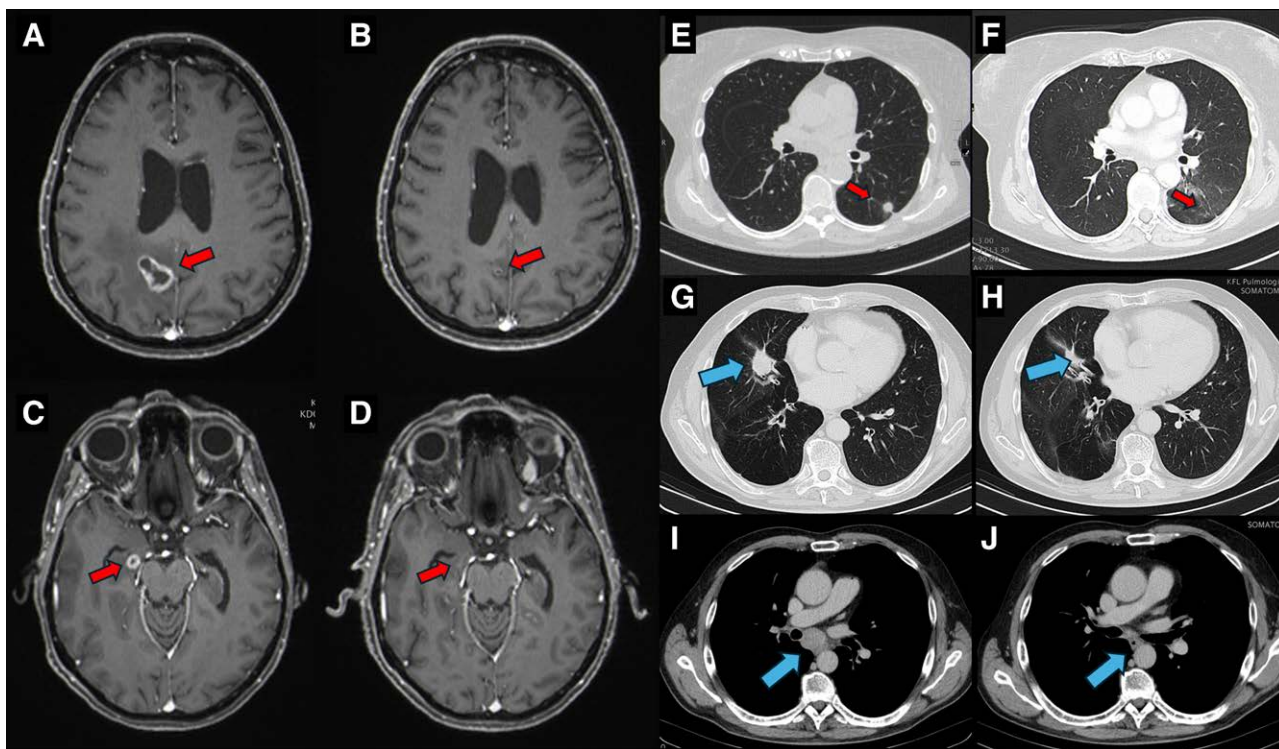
(A–F) Intracranial and systemic response (red arrows) in a 74-yr-old female patient. Contrast-enhanced T1-weighted images of the brain are shown. (G–J) Pre and posttreatment images of a 79-yr-old male with Stage IIIc adenocarcinoma, showing a PR to brigatinib in the primary tumor lesion in the right lung (G and H, blue arrows) and mediastinal lymph nodes (I and J, blue arrows). The patient subsequently underwent surgery and continued brigatinib as an adjuvant therapy. At the end of the study, the patient remained in remission. PR = partial response.
